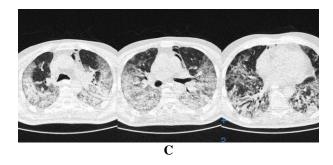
the first Chest CT-scan demonstrates peripheral ground-glass opacities in both lungs Figure 2-B. the second Chest CT scan shows pneumomesitinum in addition to ground glass opacities Figure 2-C. Chest CT-scan demonstrates resolving pneumomediastinum and progressing opacities
